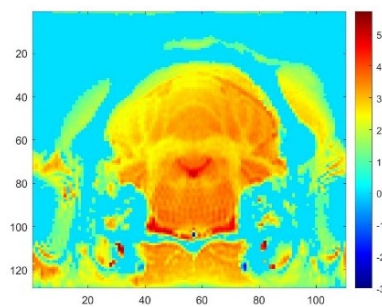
Velocity (cm/s) image acquired using FVE MRI.
